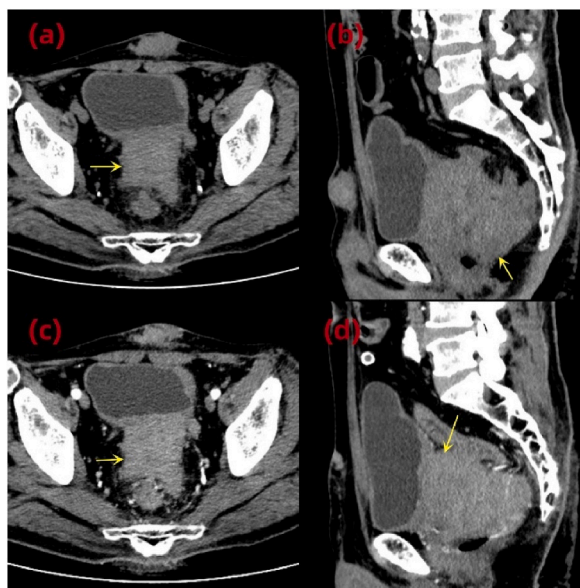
Plain CT scan of the abdomen shows diffuse lesions of the perirectal, prostate, and bilateral seminal vesicles involving the bladder wall and the left ureter (a and b, arrow). Enhanced CT of the colon shows uneven contrast-enhancing lesions (c and d, arrow).
